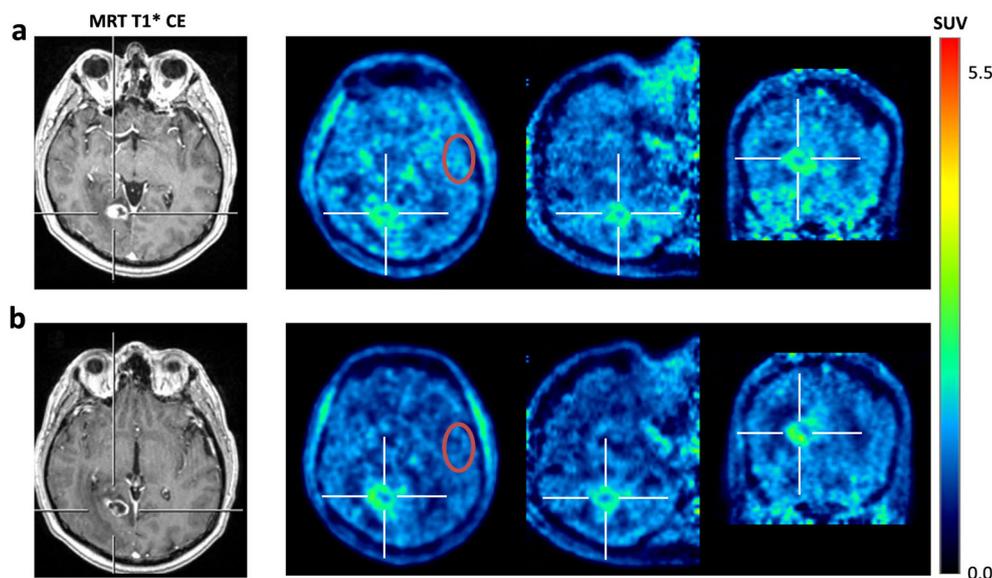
Contrast-enhanced MR images and corresponding [^{18}F]FET PET SUV images of a male patient with brain metastasis at an interval of 10 weeks. Visually, no significant tumor growth could be observed in MR or PET images. (a) At the time of first PET scan, the patient received dexamethasone. (b) Nine weeks later, dexamethasone was already discontinued and background activity was visually lower, resulting in higher tumor volume due to threshold-based VOI definition (Table 2).
